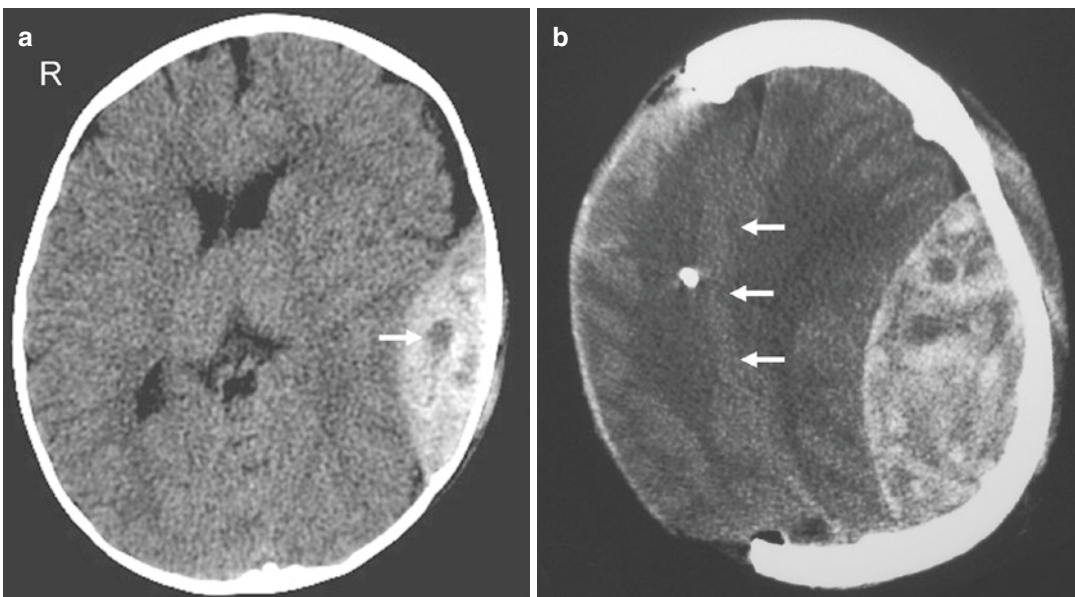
EDH “swirl sign.” (a) Axial CT image shows low attenuation areas (*arrow*) within a left frontotemporal heterogeneous acute EDH. The heterogeneous density within this EDH is secondary to mixing of hyperacute (low attenuation) with acute (high attenuation) blood. (b) Axial CT
